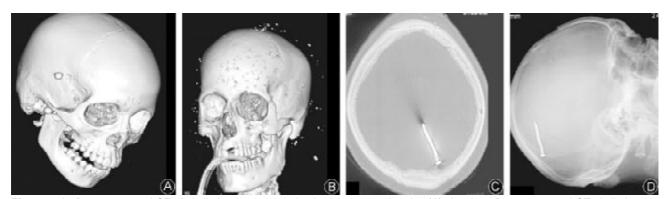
A 3D reconstructed CT of skull showing ball bearing in right temporal region (A). Another 3D reconstructed CT skull showing blast of pallets involving the head and face (B). Skull X-rays in anteroposterior (C) and lateral (D) views showing an intracranial nail used in an explosive device by a suicide bomber.
